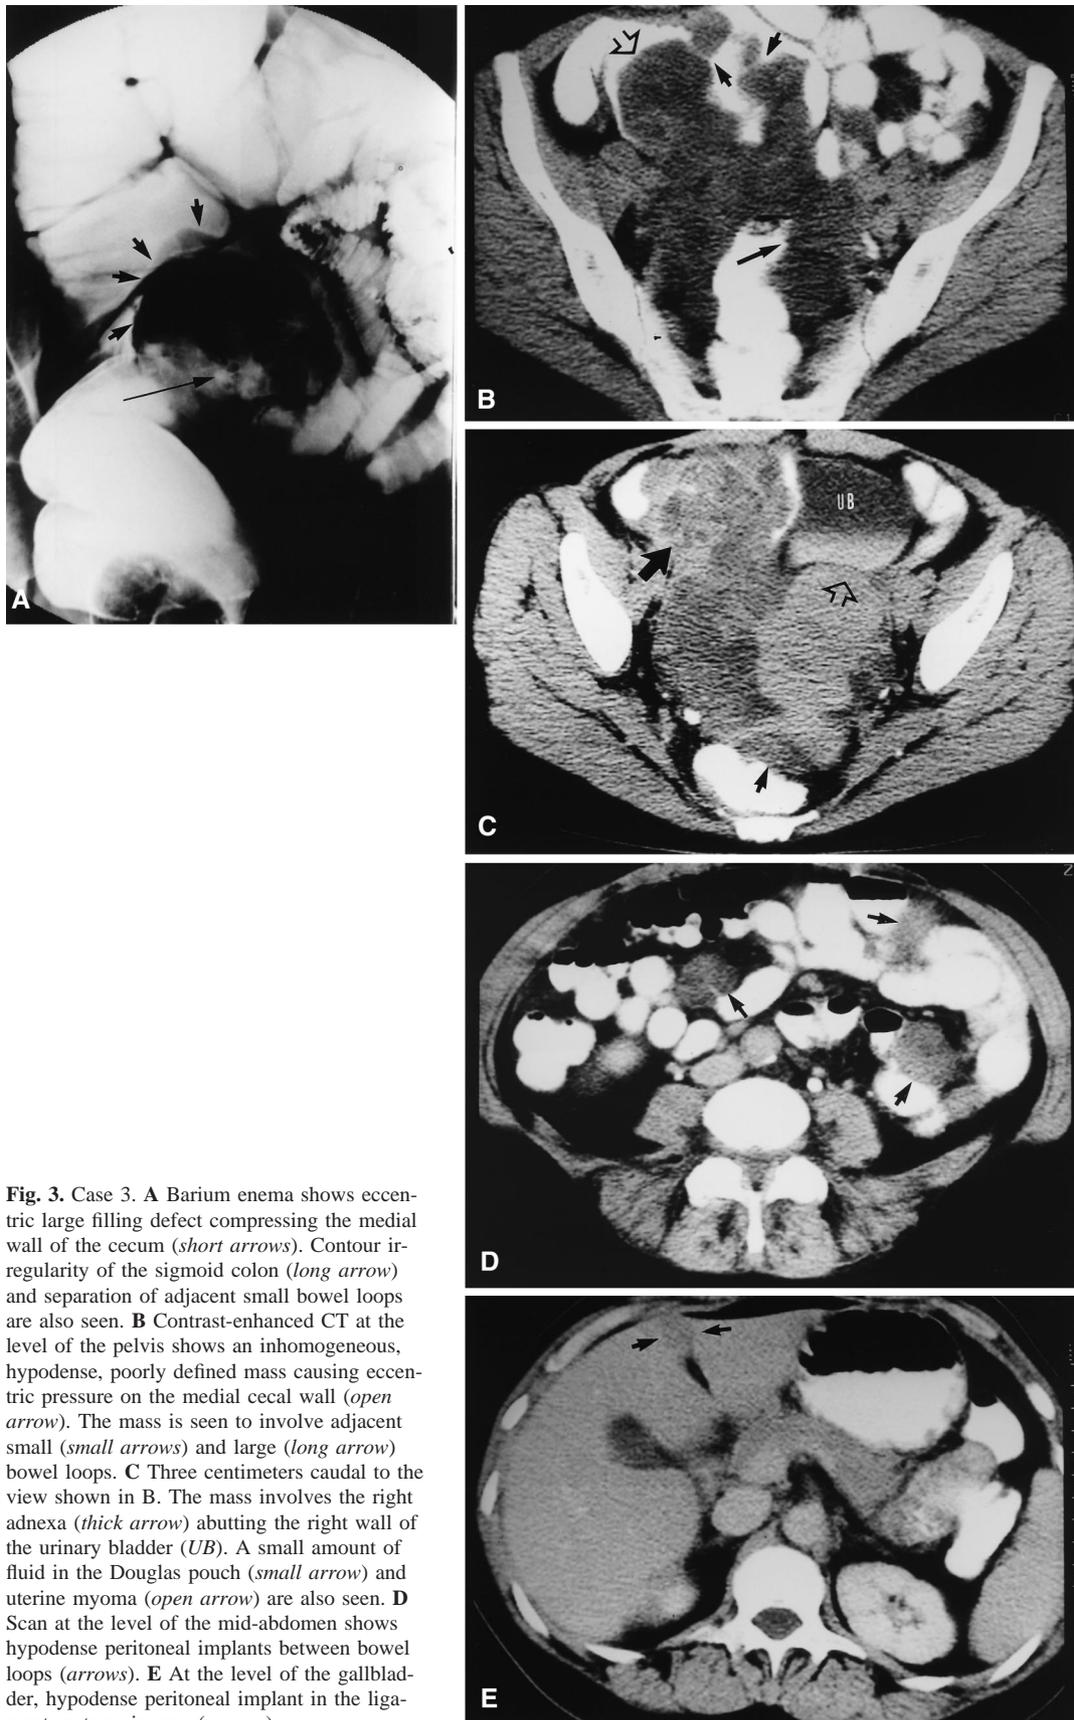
Case 3. A Barium enema shows eccentric large filling defect compressing the medial wall of the cecum (*short arrows*). Contour irregularity of the sigmoid colon (*long arrow*) and separation of adjacent small bowel loops are also seen. B Contrast-enhanced CT at the level of the pelvis shows an inhomogeneous, hypodense, poorly defined mass causing eccentric pressure on the medial cecal wall (*open arrow*). The mass is seen to involve adjacent small (*small arrows*) and large (*long arrow*) bowel loops. C Three centimeters caudal to the view shown in B. The mass involves the right adnexa (*thick arrow*) abutting the right wall of the urinary bladder (*UB*). A small amount of fluid in the Douglas pouch (*small arrow*) and uterine myoma (*open arrow*) are also seen. D Scan at the level of the mid-abdomen shows hypodense peritoneal implants between bowel loops (*arrows*). E At the level of the gallbladder, hypodense peritoneal implant in the ligamentum teres is seen (*arrows*).
